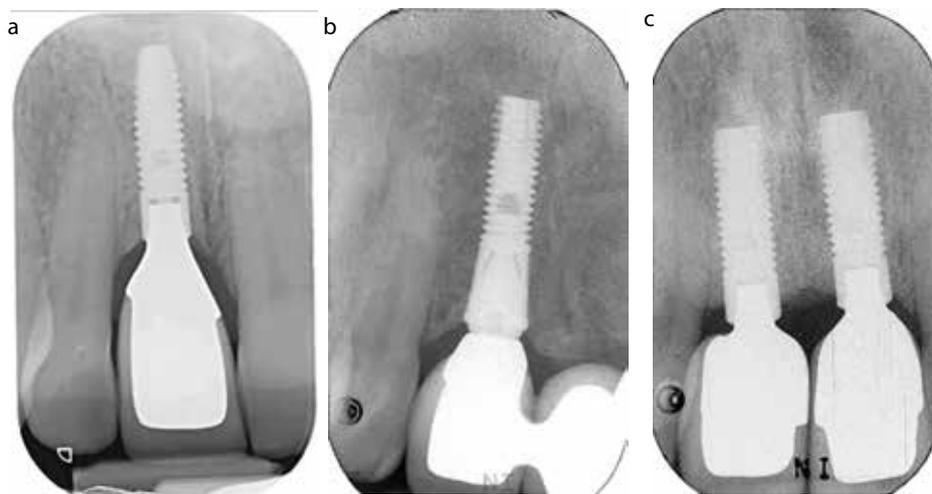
(a–c) Periapical radiographs of implants relating to Cases 1–3, respectively.
